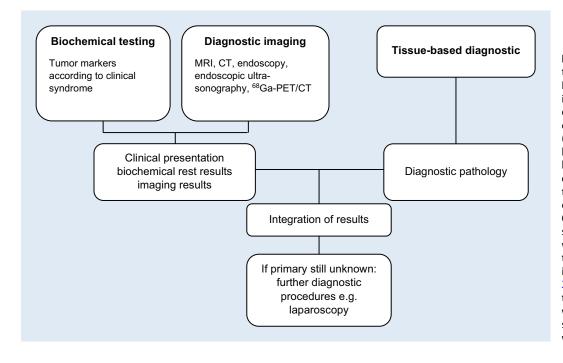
< Adapted diagnostic algorithm proposed by Hendifar et al. [22]. According to them, ⁶⁸Ga-positron emission tomography/ computed tomography (68Ga-PET/CT) should be considered if there is biochemical or clinical evidence of a neuroendocrine tumor but the primary cannot be found by using OctreoScan. However, the superiority of ⁶⁸Ga-PET/CT was demonstrated and therefore recommended instead of OctreoScan [26, 29, 30]. Diagnostic modalities were further expanded with endoscopy and endoscopic ultrasonography as well as laparoscopy [19, 35]
